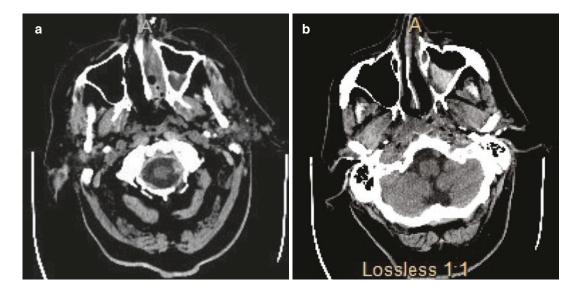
(a, b) Non-contrast CT head demonstrating left nasal intubation with associated hemorrhage and blood products in the left maxillary antrum. Embolization was requested and performed. Patient's right groin was prepped and draped in usual sterile fashion. Right common femoral artery found to be patent by ultrasound (c). Ultrasound image archived. (c) Access was then obtained by Seldinger technique. A 5-French Berenstein catheter was advanced through the sheath into the aortic arch and the left common carotid artery was selectively catheterized. Digital subtraction arteriograms (DSA) were then obtained. (d) DSA of the left common carotid artery arteriogram. A microcatheter was then advanced into the left external carotid artery and eventually into the left internal maxillary artery. (e) DSA image demonstrating bifurcation into the left superficial temporal artery and proximal aspect of the left internal maxillary artery. (f and g) sagittal and coronal section-Microcatheter was advanced into the distal left internal maxillary artery near the bifurcation of the internal maxillary artery into the sphenopalatine
